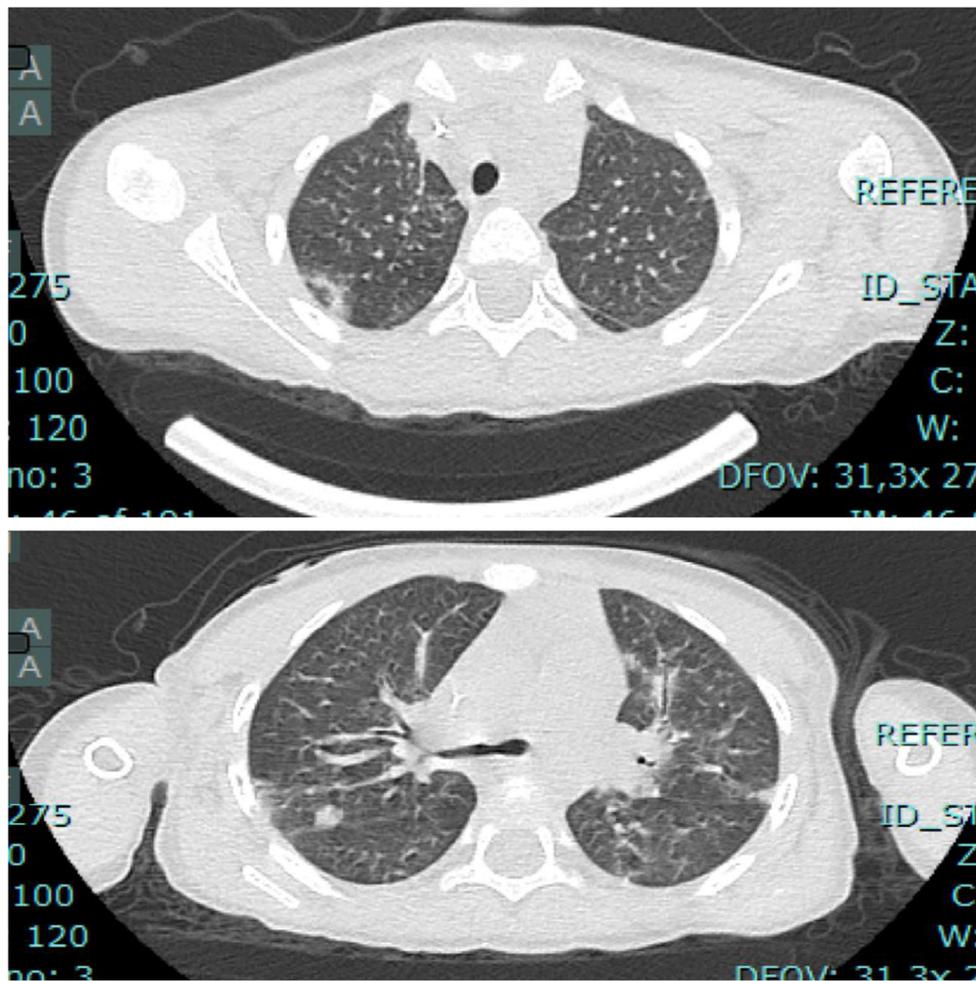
Hi resolution Chest CT showing multiple bilateral pulmonary nodules and small bronchiectasis.
